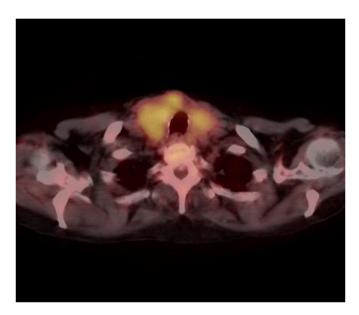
Thyroid PET CT image.
